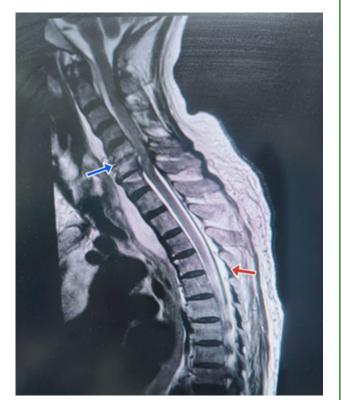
MRI of the spine showing C5-C6, C6-C7 discitis (marked using blue arrow) with cervical prevertebral, paravertebral and epidural abscess at C2-T3 level (marked with the red arrow) leading to cervical cord compression.
